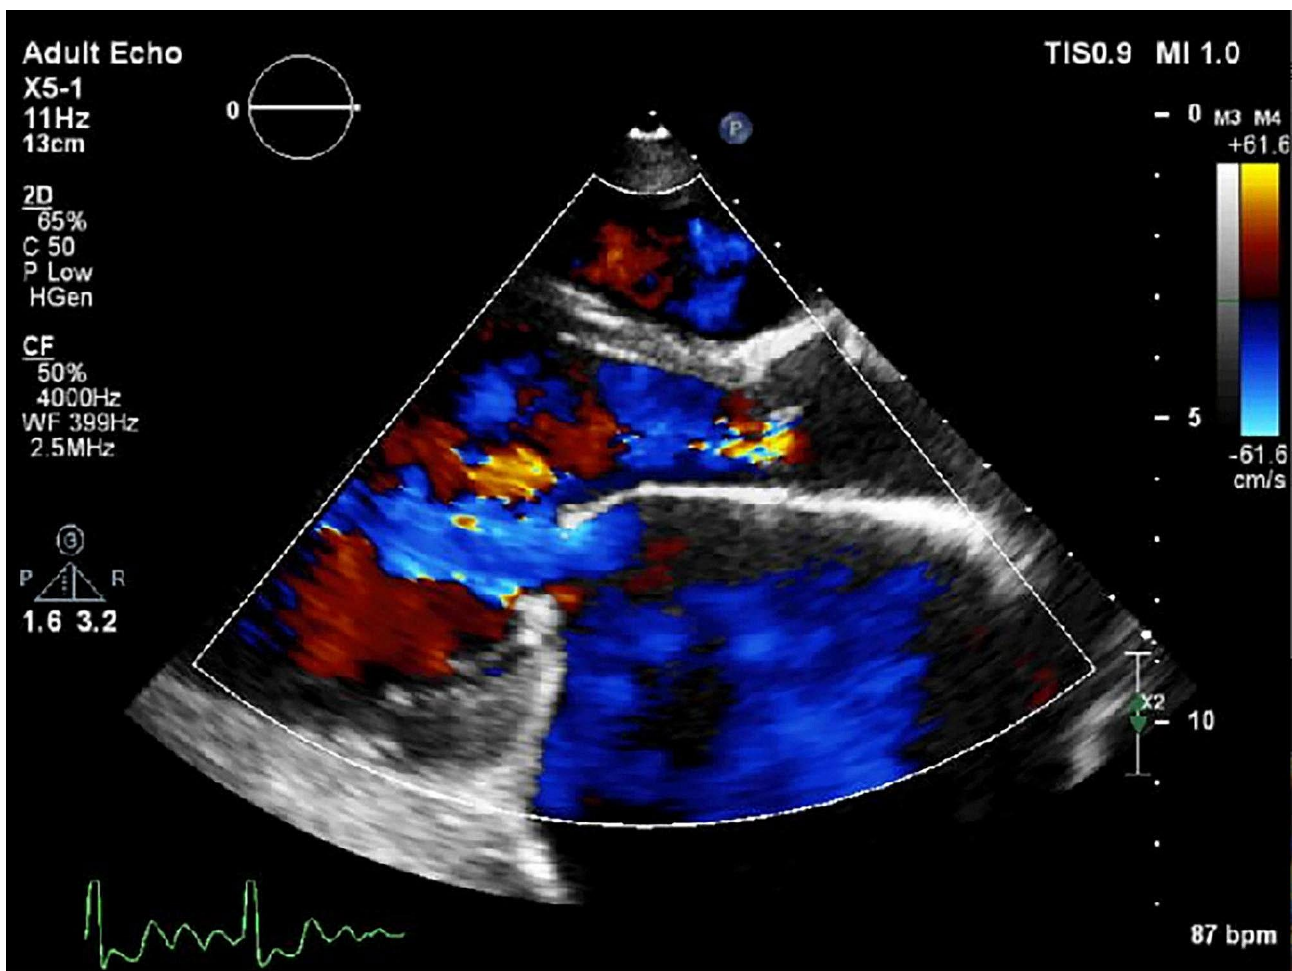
Preoperative ultrasound diagnosis (mitral insufficiency). The anteroposterior diameter of the mitral ring was 40 mm, the left and right diameters were 34 mm, the lobe was thickened, contracture, calcification, and enhanced echo, especially with obvious valve tip, junctional adhesion, open diameter about 7 mm, and thickened subvalvular tendinous cords. Due to the limited opening, the area of the valve opening was estimated to be about 1.6 cm^2 by the cartography method, and the closure was seriously unclosed
